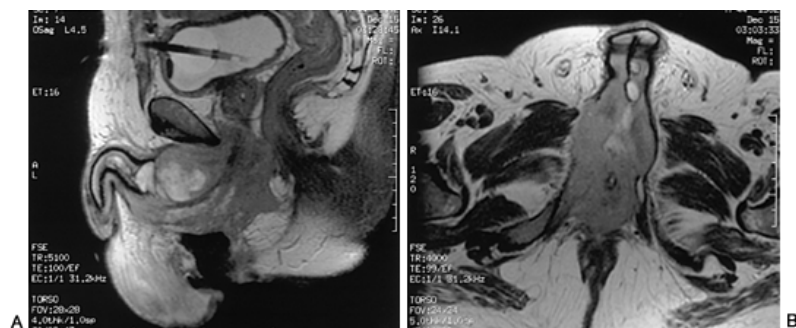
Magnetic resonance imaging scan of male urethral carcinoma: A: Sagittal T₂-weighted image demonstrates extension to the prostatic capsule, pubic symphysis, and anus and invasion of corpora cavernosa. B: Axial T₂-weighted image of the same lesion demonstrates possible involvement of the right pectineus, adductor longus, and adductor brevis muscles.
